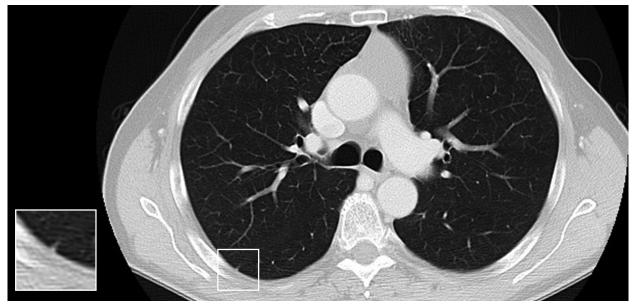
Transversal CT section image 28: The observable features of the false positive as depicted by the transversal CT.
